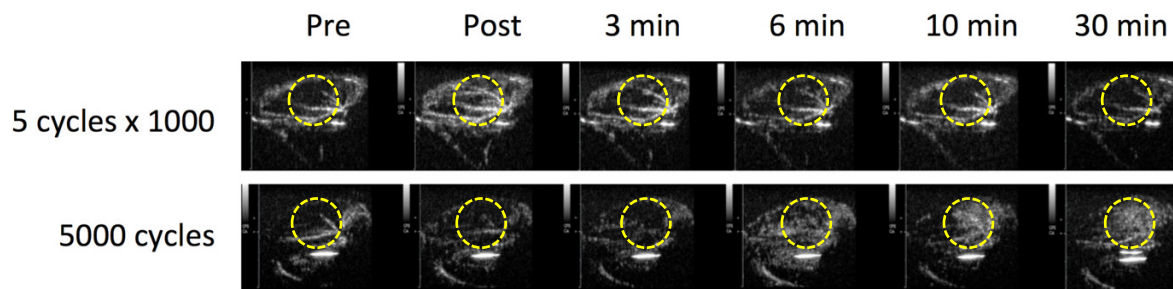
Typical still frames taken 1s post burst in burst reperfusion cine-loops at different time points after SRP therapy using either short or long pulse therapeutic ultrasound. Yellow circles indicates location of therapeutic ultrasound beam
